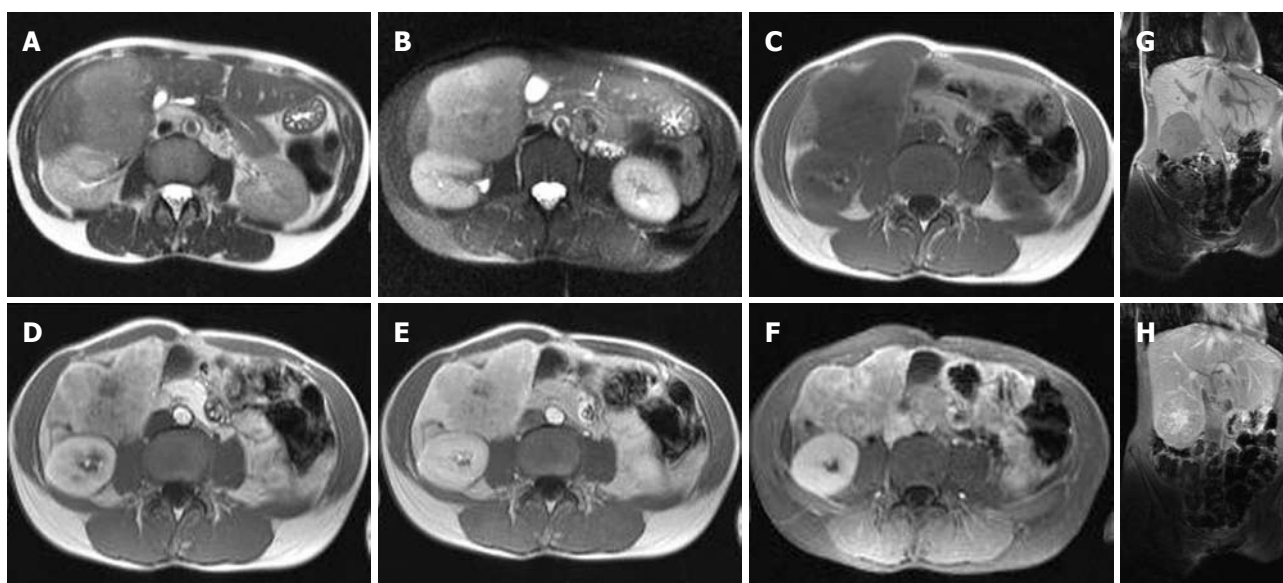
MRI images of combined hepatocellular and cholangiocellular carcinoma. Axial T2 (A) and T2 fat saturated (B) MRI images showed a slightly well circumscribed lesion. The mass is hyperintense in comparison to the normal liver. Axial T1 (C) MRI images demonstrated a hypointense lesion. Early arterial (D), late arterial (E) and venous (F) MRI images displayed a hypervascular heterogeneous enhancement with central scar. The coronal T1 (G) image showed a hypointense lesion, while the coronal T1 MRI image after Gadolinium contrast (H) demonstrated a heterogeneous early enhancement of the lesion with delayed uptake in the scar.
